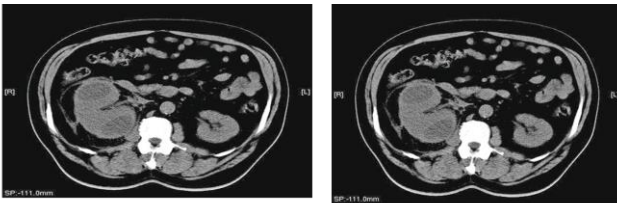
CT of kidney: abscess of right kidney (two sites with distinct contours density in whole 18-22 HU, around which formation of pyogenic capsule is observed)
